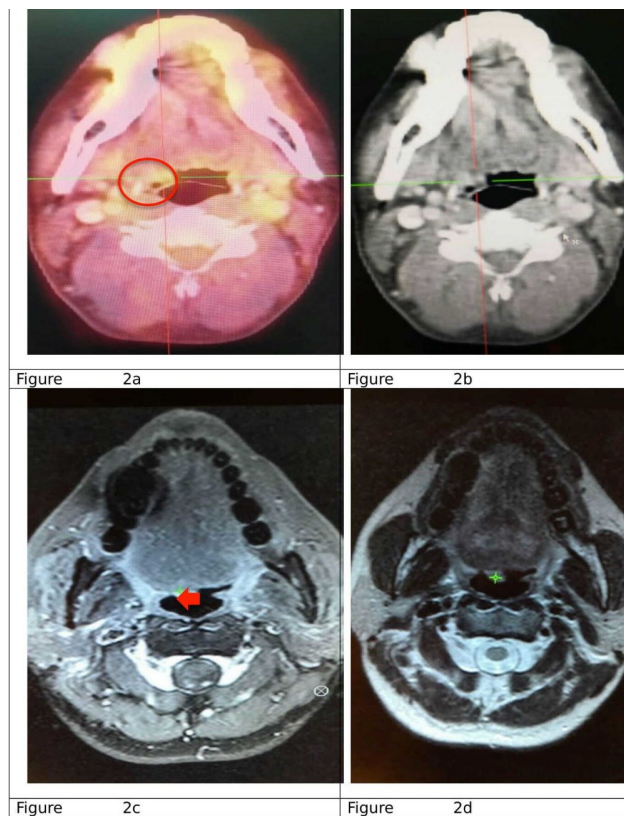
Axial Fused 18F FDG PET-CT (left) & CT (right) images show an FDG-avid lesion (SUVmax: 3.23 ng/l, size: 1.0 cm). The round marker shows the involvement of the right side of the vallecula. The correlated contrasted CT (2b) shows that the lesion is hypodense with minimal enhancement. Figure 2c & 2d. Axial contrasted T1 post-Gadolinium MRI and T1-weighted images show an enhanced soft tissue low-intensity lesion in the right side of the vallecula with an indistinct margin (arrow)
